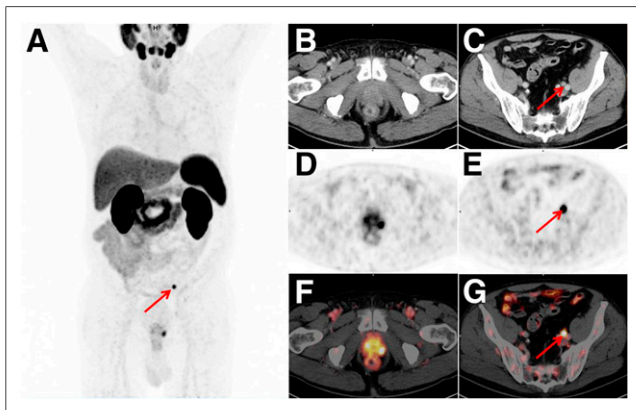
Set of images from 71-y-old patient (Gleason score of 10, initial prostate-specific antigen level of 1.15 ng/mL). (A) Whole-body maximum-intensity projection displays local tumor and 1 suspected lesion (arrow). Local tumor is not detectable on CT (B) but shows increased tracer uptake on ^{18}F -rhPSMA-7 PET (D) and PET/CT (F). CT (E) reveals suggestive finding (arrow), with 8-mm lymph node ventral to left external iliac vein; corresponding ^{18}F -rhPSMA-7 PET (E) and PET/CT images (G) show intense uptake with high lesion-to-background ratio in this small lymph node, indicating lymph node metastasis. Radical prostatectomy with extended pelvic lymph node dissection confirmed single lymph node metastasis.
